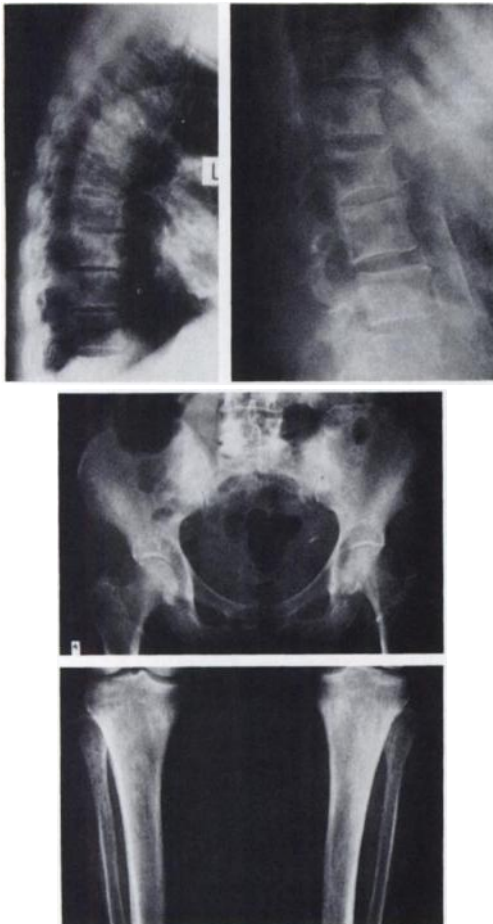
Radiographs demonstrating sclerosis and thickening of trabeculae compatible with mastocytosis: lateral dorsal spine (upper left), lateral lumbar spine (upper right), pelvis (center), and proximal tibiae and fibulae (bottom).
